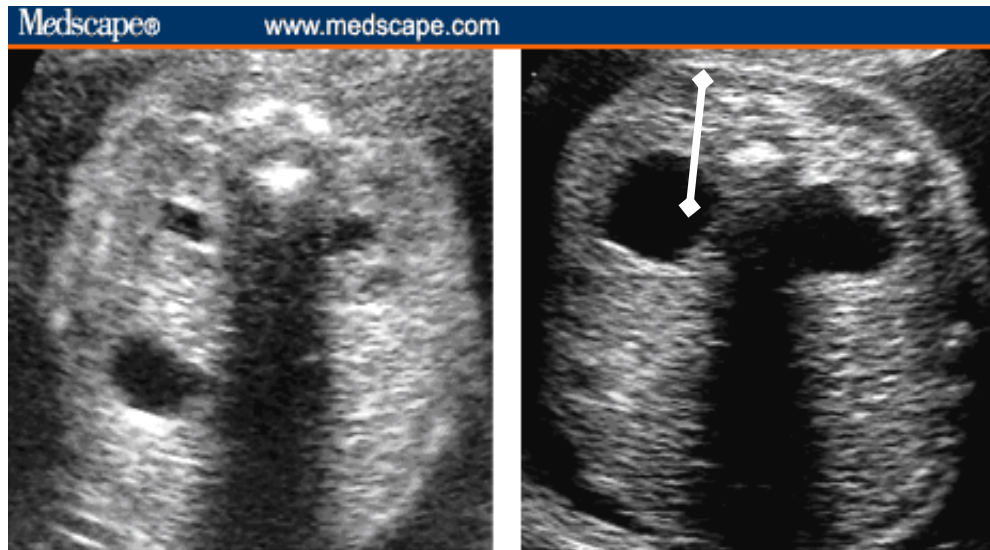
Pyelectasis in the early second trimester. The left sonogram shows the normal sized renal pelvis, while the right photo shows a large dilation of the renal pelvis (pyelectasis).
